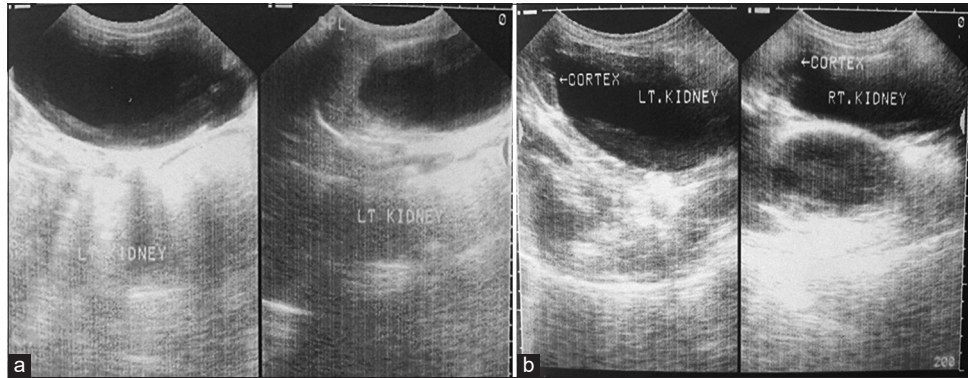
(a and b) Ultrasonographic (USG) image of hydronephrosis
